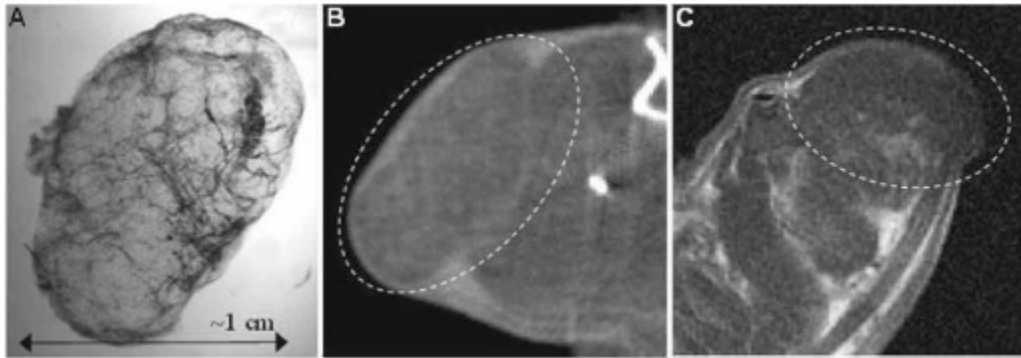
Figure showing the advantage of OptCT imaging over other modalities. Part (A) shows a projection image of a HCT116 tumour after optical clearing. (B) is an *in vivo*  $\mu$ -CT image of the same tumour with  $50\mu\text{m}$  resolution. (C) is *in vivo* T1 weighted contrast enhanced  $\mu$ -MRI image of a similar tumour. The superior resolution and contrast in the OptCT image is evident. Images adapted from [38].
